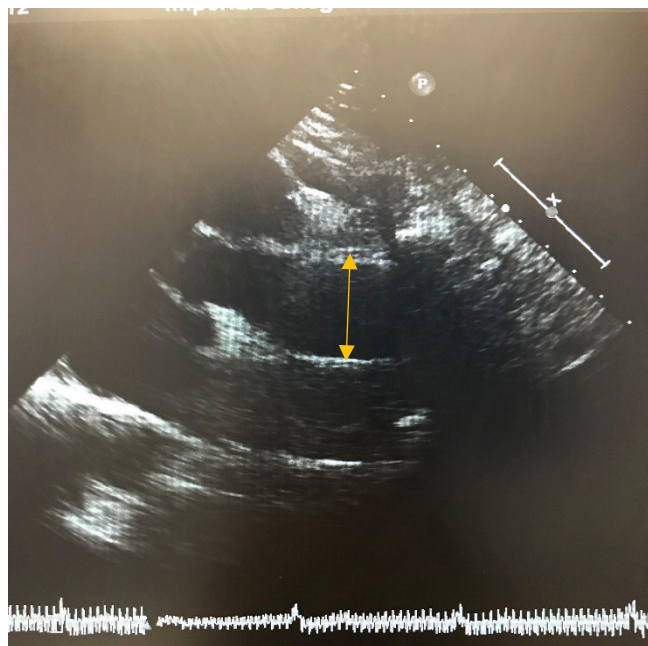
Parasternal long axis view of the ascending aorta
